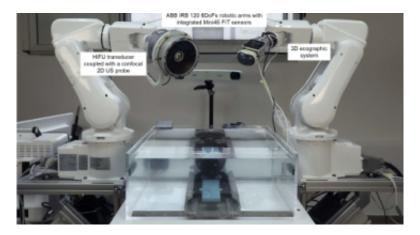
FUTURA platform for high-intensity focused ultrasound surgery[8]
